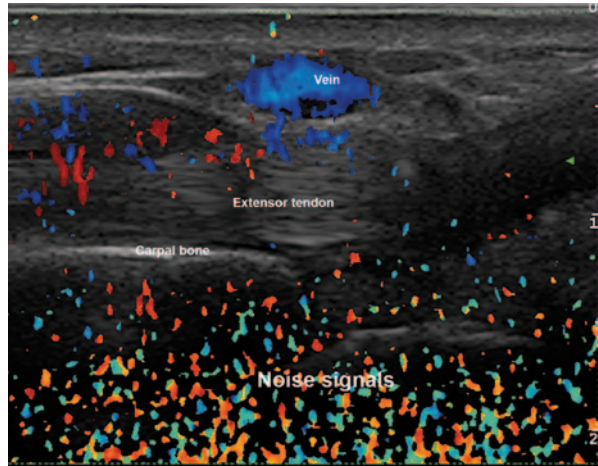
Longitudinal view of the dorsal side of carpal joints. The Doppler gain is set “too high,” so a lot of signal noise appears below the bone contour and below the vessel. To adjust the image, the Doppler gain should be lowered until all signals below the bone disappear
